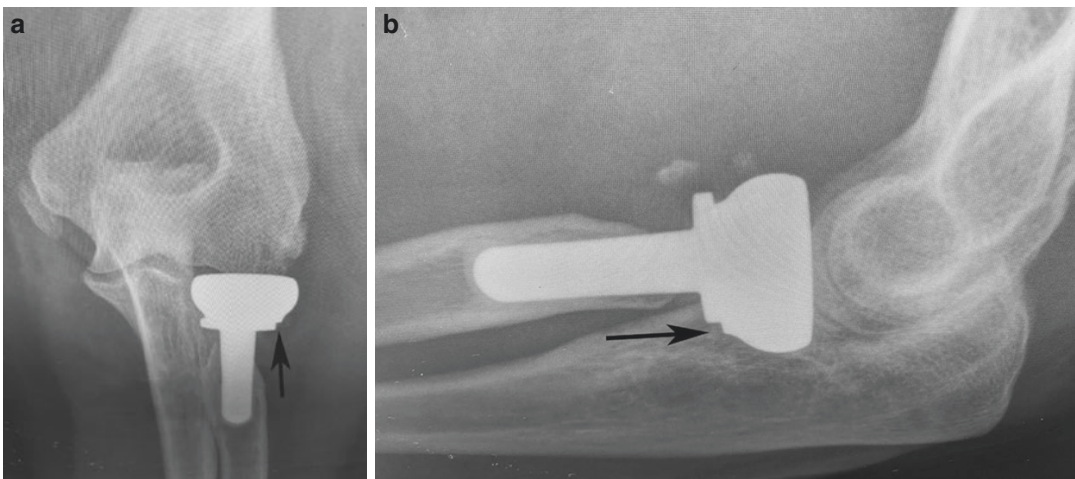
(a–b) Anteroposterior (a) and lateral (b) radiographs showing loosening of the radial head component relative to the stem. The radial head is slightly laterally (a) and posteriorly (b) shifted (arrows) relative to the stem
